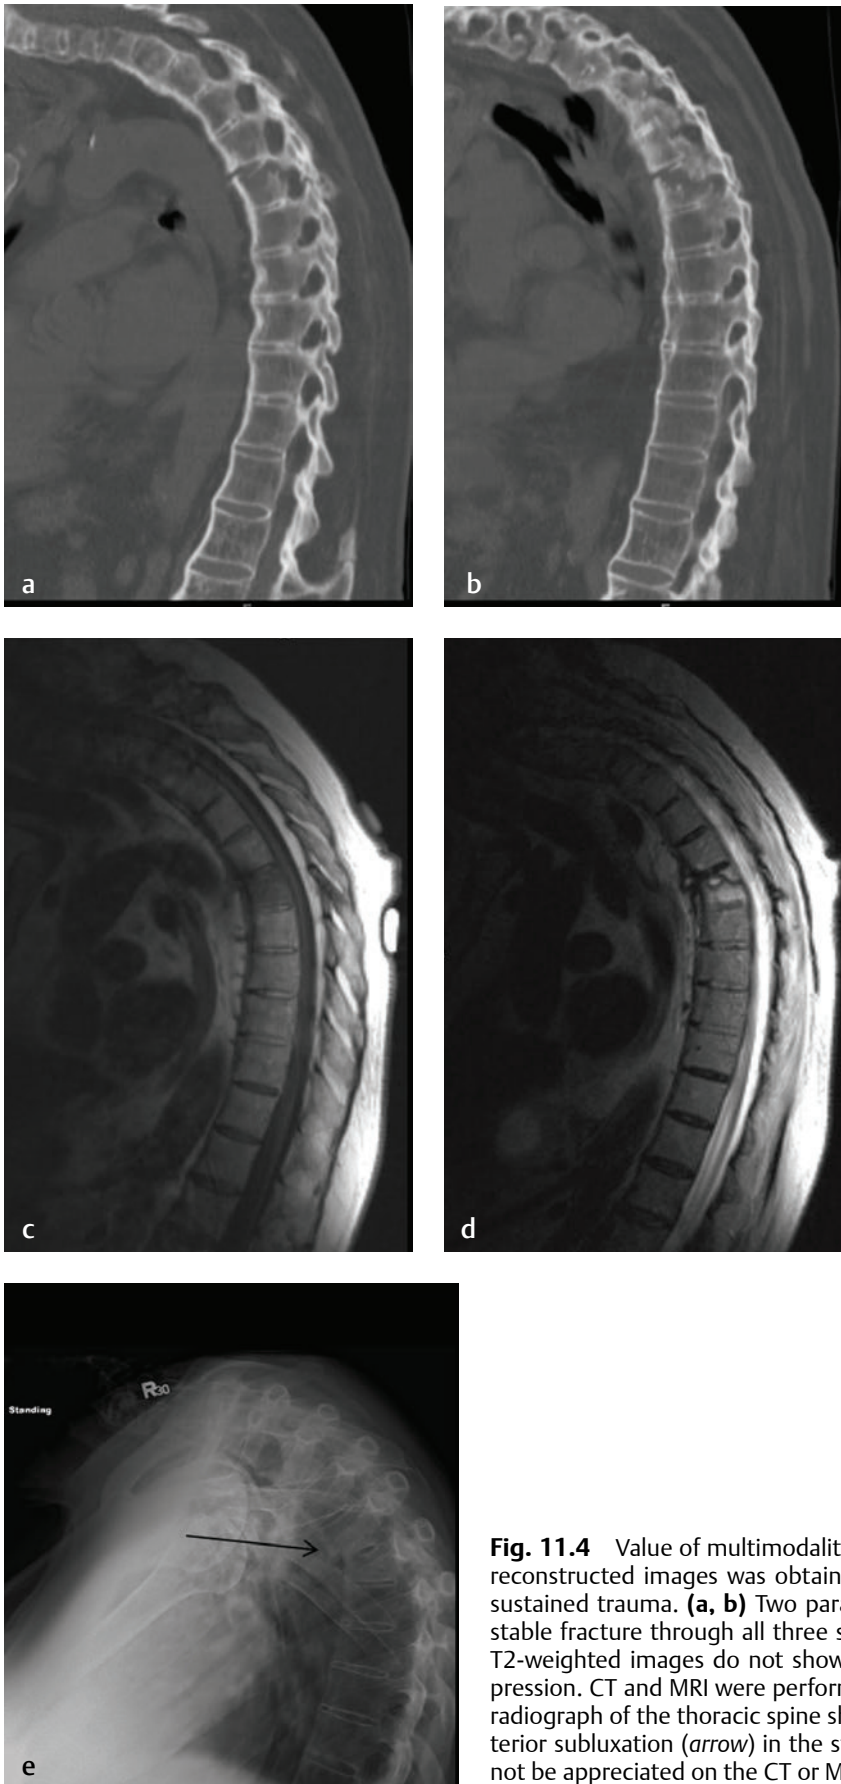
Value of multimodality imaging. Noncontrast CT imaging with sagittal reconstructed images was obtained in a patient with ankylosing spondylitis who sustained trauma. (a, b) Two parasagittal reconstructed CT images show the unstable fracture through all three spinal columns. (c) Sagittal T1-weighted and (d) T2-weighted images do not show epidural hemorrhage, cord contusion, or compression. CT and MRI were performed in the supine position. (e) A standing lateral radiograph of the thoracic spine shows the unstable nature of the fracture with anterior subluxation (arrow) in the standing position; the dynamic component could not be appreciated on the CT or MR images.
